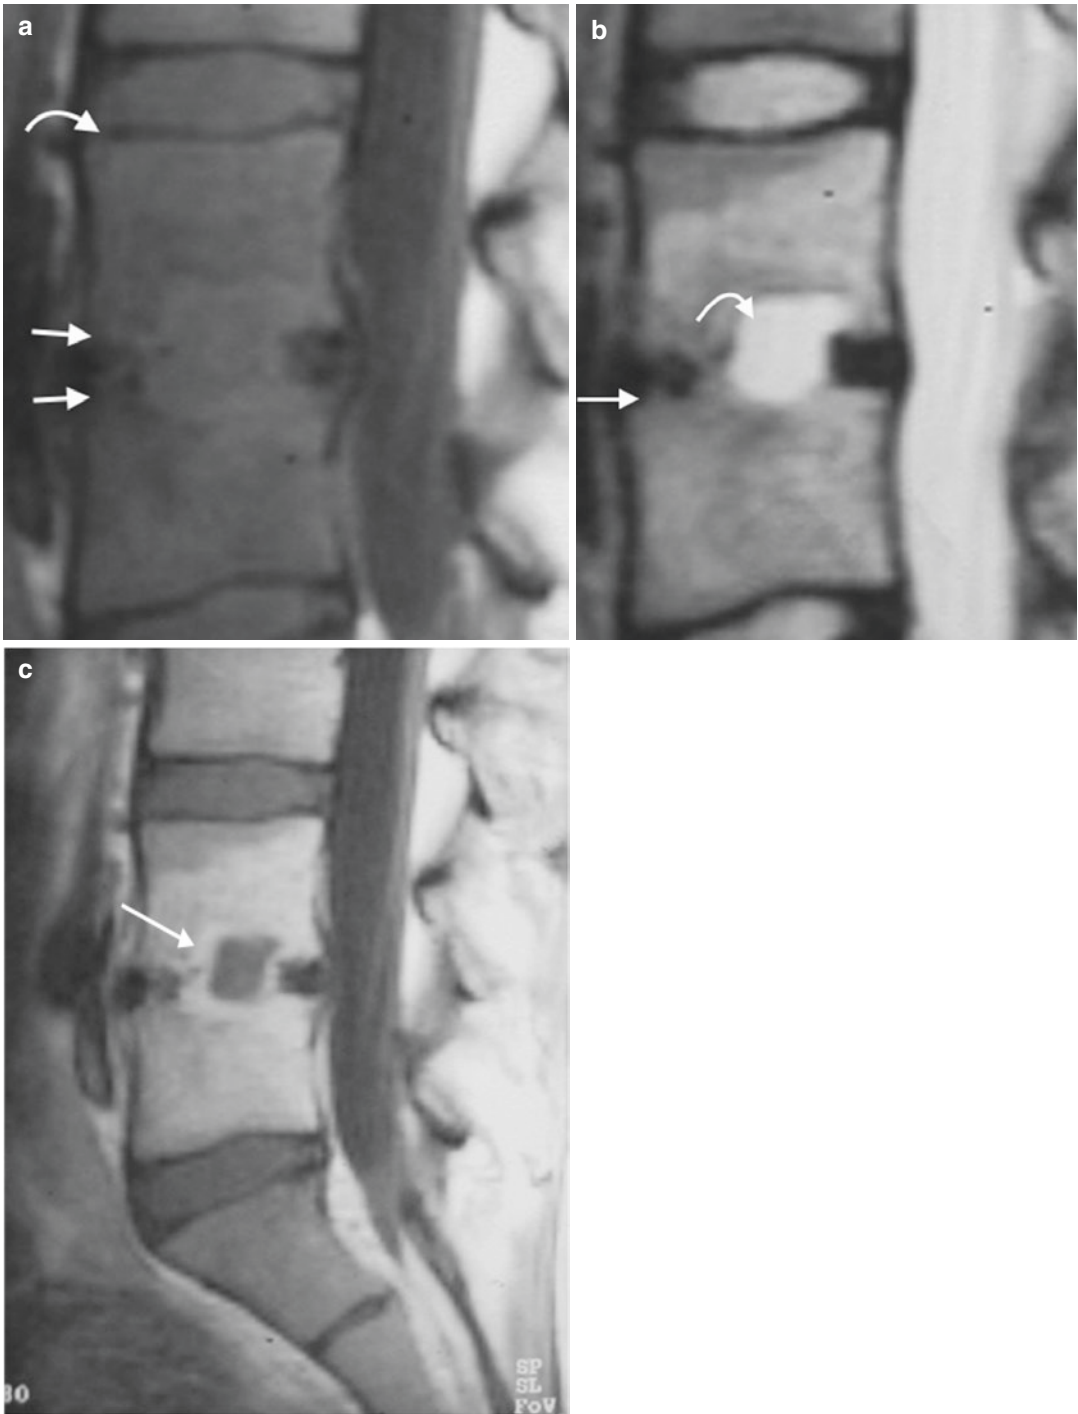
MRI signs of early disk space infection. T1-weighted sagittal image (a) shows loss of the hypointense lines (arrows) that correspond to the vertebral endplate; compare to the normal vertebral endplate at the level above (curved arrow). T2-weighted sagittal image
